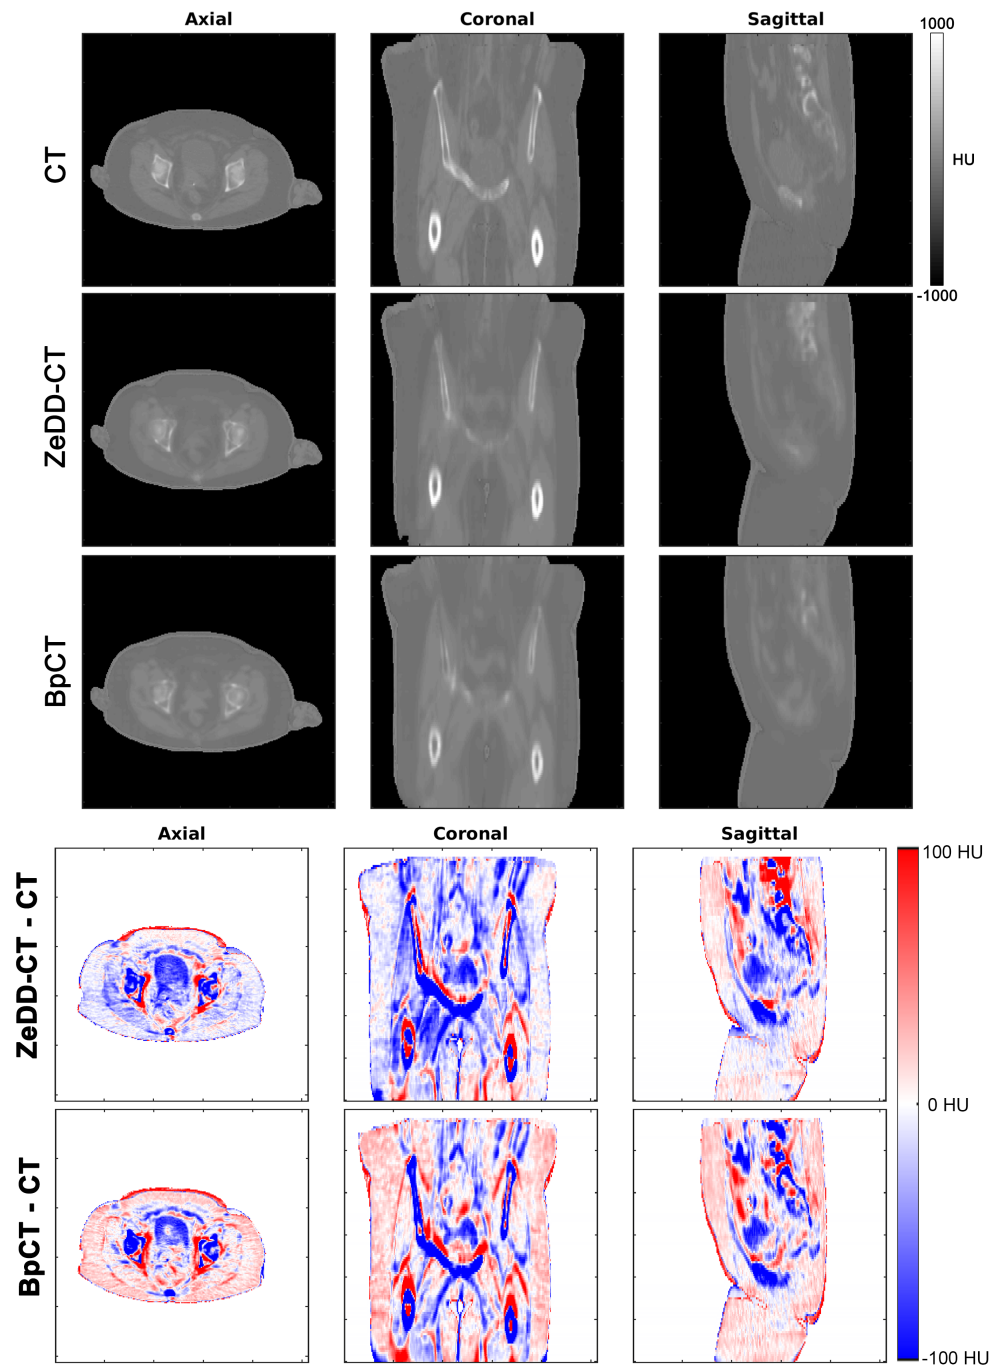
CT and difference images of pseudo-CT images for one representative case without implants. Both ZeDD-CT and BpCT have the least RMSE for this patient (RMSE=98.5 HU, and RMSE=98.9 HU, respectively).
